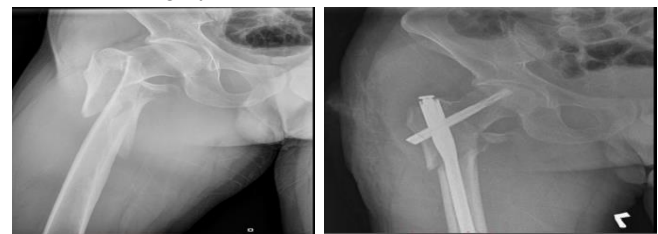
Pre and post op radiographs of 65-year-old lady treated with PFN.
